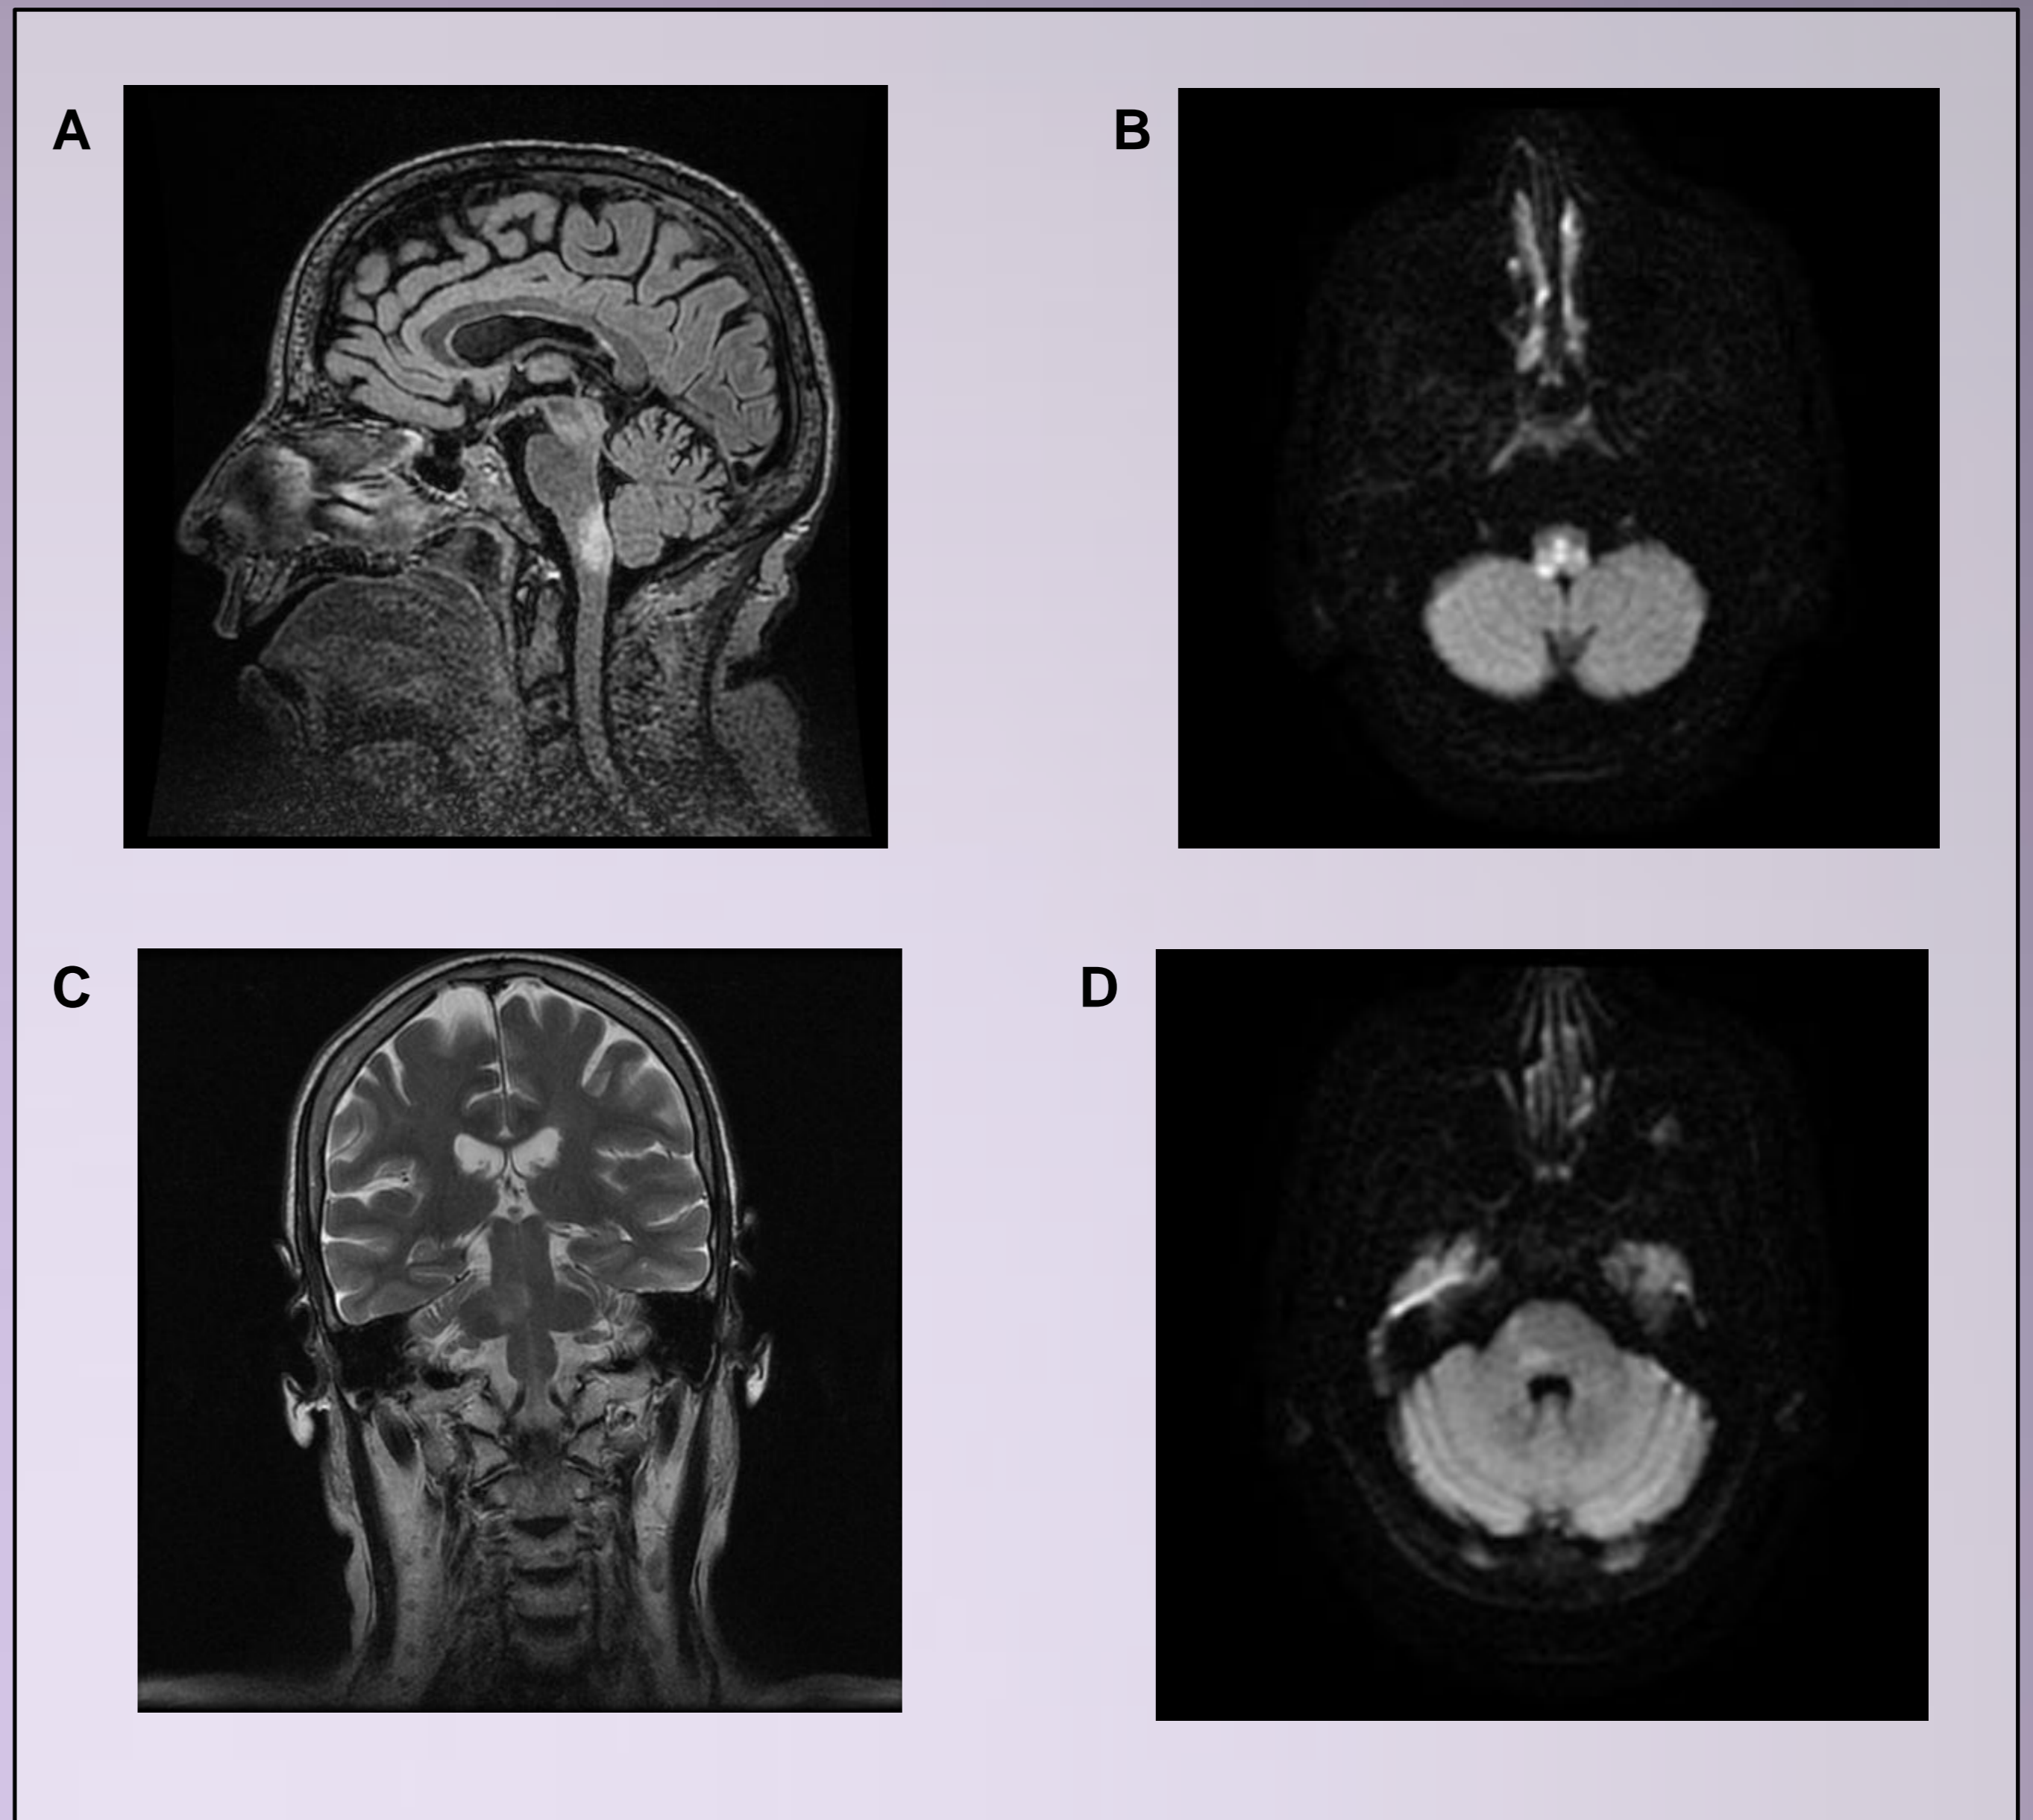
Figure legend: Sagittal brain T2 weighted (A) and axial DWI (B) MRI showing a focus of high signal in the posterior medulla. Coronal brain T2 weighted FLAIR (C) and axial DWI (D) MRI showing a pontine lesion.
